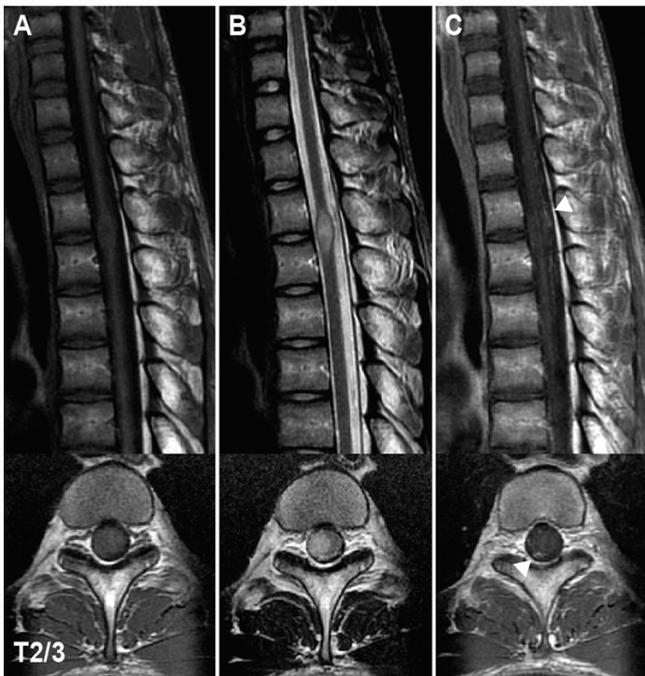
Sagittal (upper panels) and axial (lower panels) MRI studies demonstrating an intramedullary tumor at the level of T2–3. The tumor is isointense on T1-weighted images (A) and hyperintense on T2-weighted images (B). The Gd-enhanced T1-weighted MR images (C) demonstrate a partially enhanced area on the right dorsal spinal cord (arrowheads).
